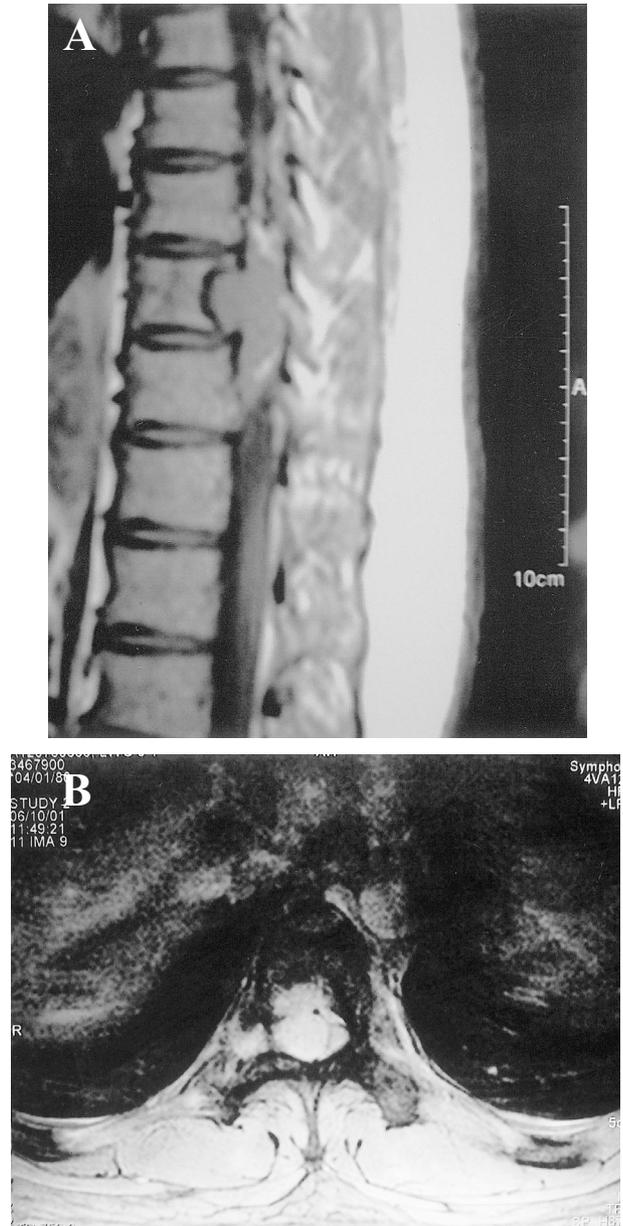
MR images revealing a tumor at T8 with a marked erosion defect in the posterior portion of the T8 vertebral body. The tumor occupied the right anterolateral region of the spinal canal of T8 and had pushed the spinal cord to the opposite side. (A) T1-weighted sagittal view; (B) T2-weighted, horizontal view.
